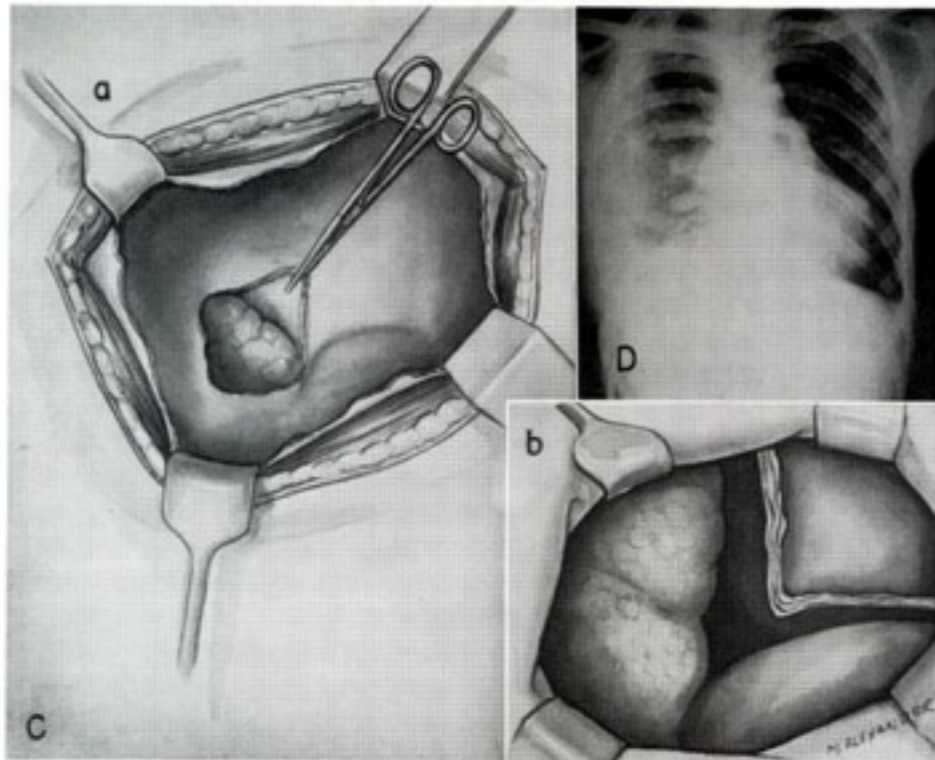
Continued. C. Technique of right pulmonary decortication: (a) Appearance of totally collapsed right lung, which is completely immobilized by thick sheet of organizing fibrin and exudate, so that individual structures are scarcely discernible. After initial sharp dissection, a small flap of thick, organizing peel has been elevated by blunt dissection. Positive pressure has caused a slight herniation of lung through opening. (b) Mobilization of lung and diaphragm after complete decortication of visceral pleura. Visceral pleura is essentially normal and lung is expansile but not yet completely reexpanded. The ridge represents line along which thickened fibrous rind was reflected from visceral onto parietal pleurae. D. Posteroanterior roentgenogram 14 days after decortication. All drainage has ceased, and lung now completely fills pleural cavity.
